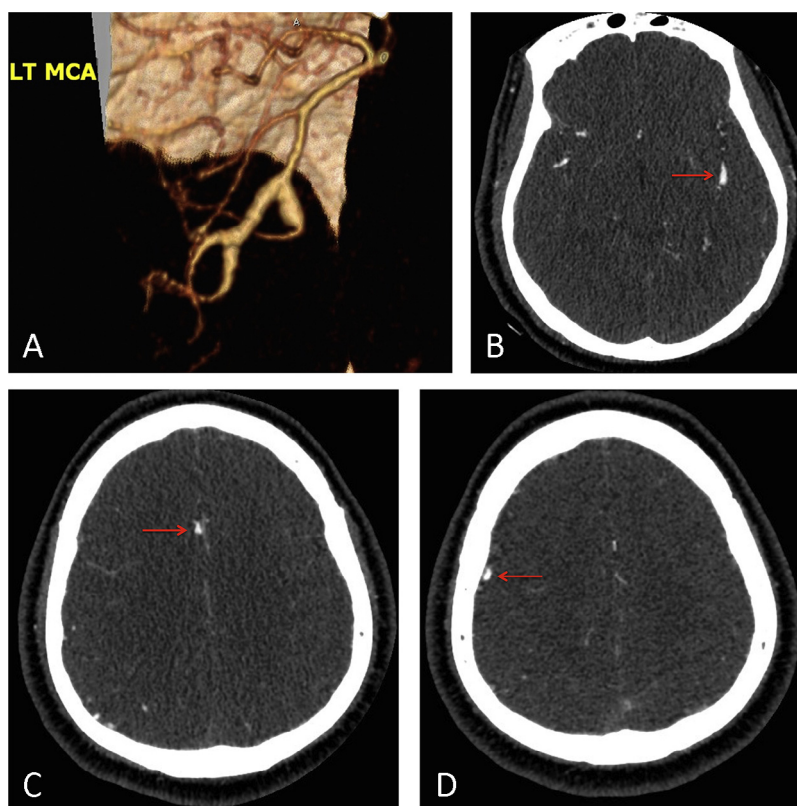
(A) Three-dimensional reconstruction from CTA head and neck demonstrates second- and third-order left MCA branch vessel ectasia. (B) Axial CT image from the same CTA study shows the 4.6-mm aneurysmal left MCA M2 segment. (C) An axial CT image from the same study also demonstrates 3-mm ectasia of a distal branch of the right ACA. (D) Shows another ectatic vessel in the posterolateral right frontal lobe. ACA, anterior cerebral artery; CT, computed tomography; CTA, computed tomography angiogram; MCA, middle cerebral artery.
